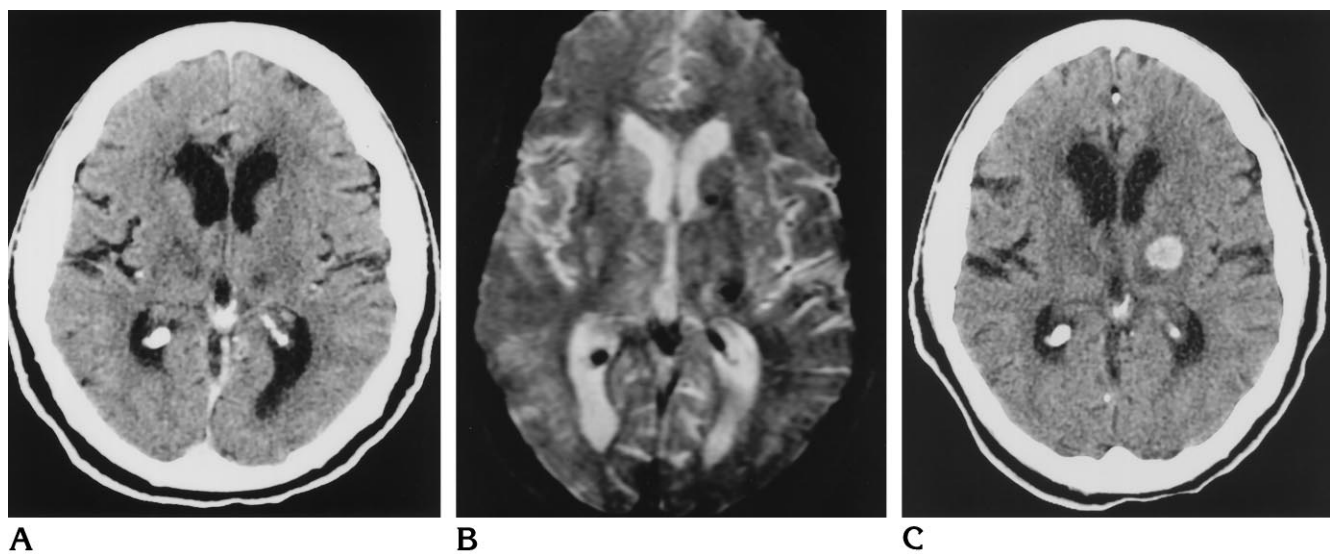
A, Axial CT scan of a patient with chronic hypertension and previous strokes indicates two lesions of decreased attenuation within the left and right thalamus, respectively. No evidence of acute hemorrhage is seen.
